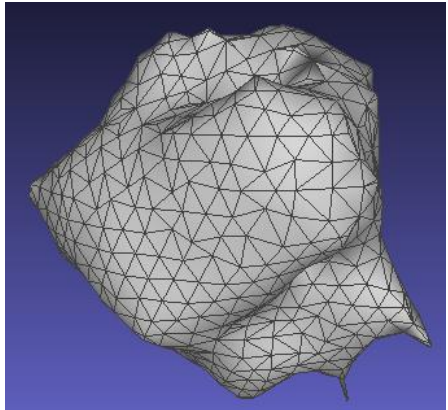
STL of the segmented tumor from MRI 05 using three smoothing steps in the Laplacian Smoothing tool in *Meshlab*.
